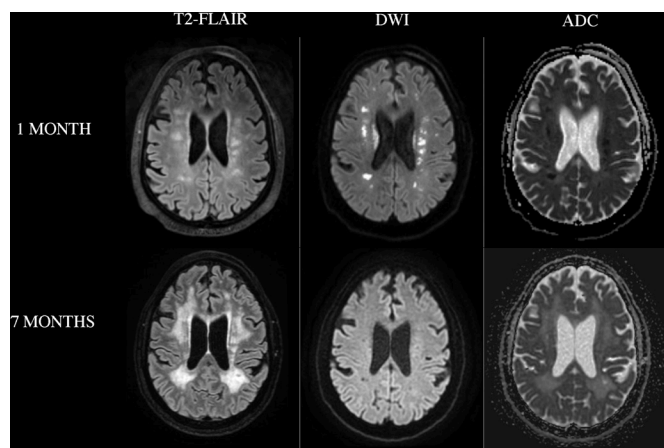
MRIs depicting white matter hyperintensities at 1 and 7 months after COVID-19 symptom onset: (1 month) T2-weighted Fluid Attenuated Inversion Recovery (T2-FLAIR), Diffusion-Weighted Imaging (DWI) and Apparent Diffusion Coefficient (ADC) map images captured by Siemens Magnetom Skyra 3 T; (7 months) same as above captured with GE Healthcare Signa Artist 1.5 T.
